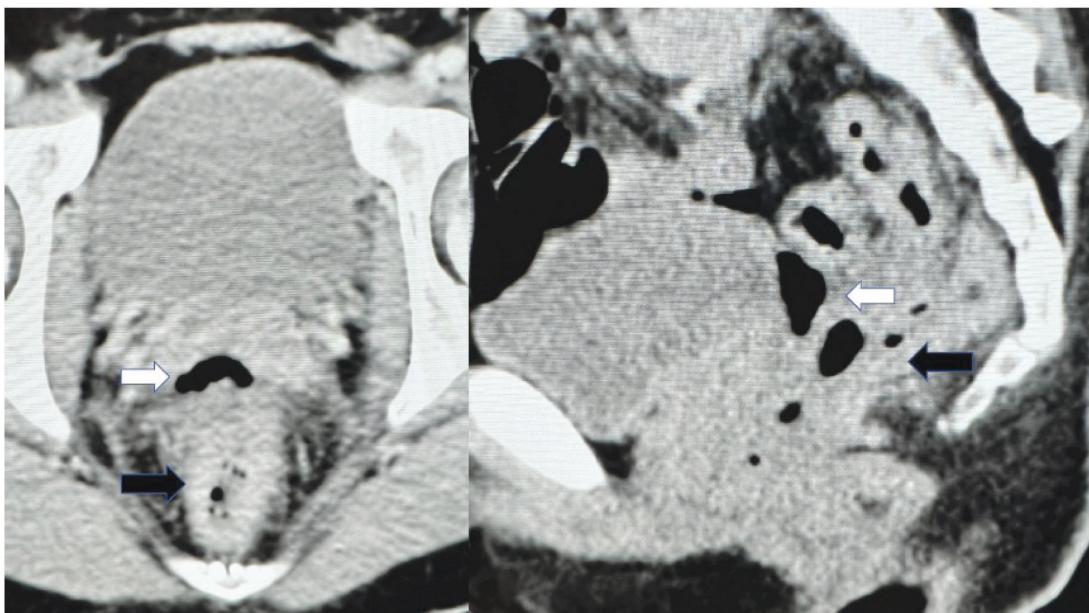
Contrast-enhanced CT scan without intraluminal contrast of extraperitoneal rectal injury (left; axial view, right; sagittal view)
